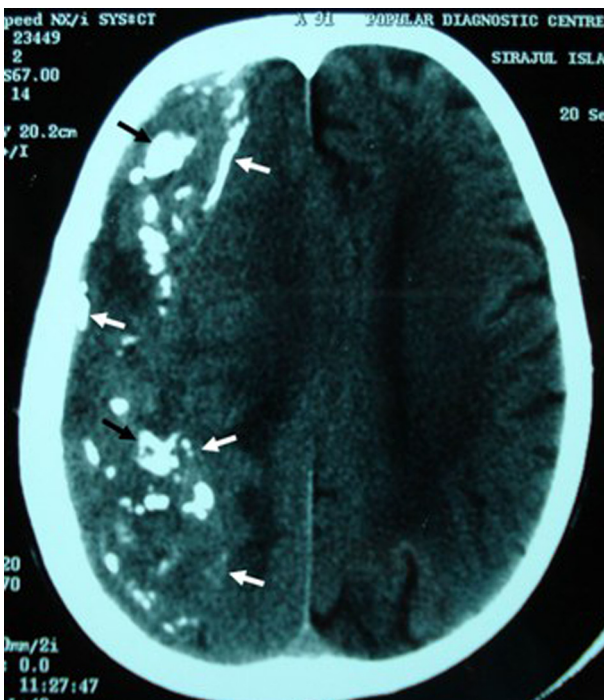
CT scan of head showing right fronto-temporo-parietal huge CCSH with calcification of the inner and outer membranes (white arrows) and calcification inside (black arrow).
